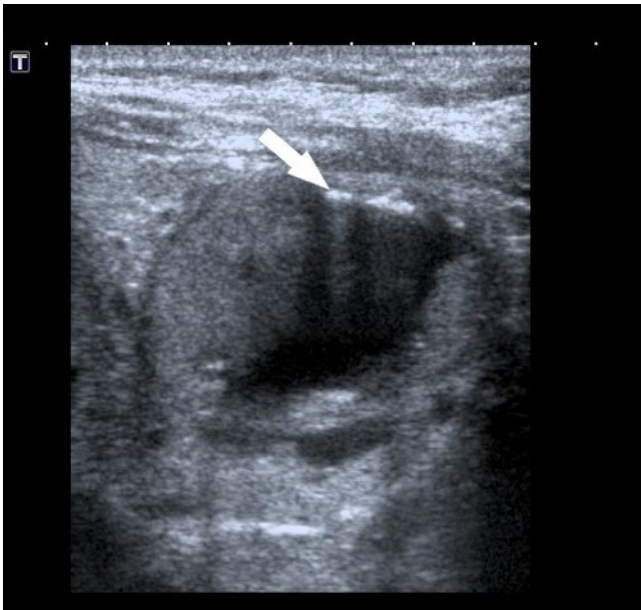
On cervical ultra-sonography, there was a thick-walled cystic lesion with echogenic air values in the anterior of the left lobe of the thyroid gland.
